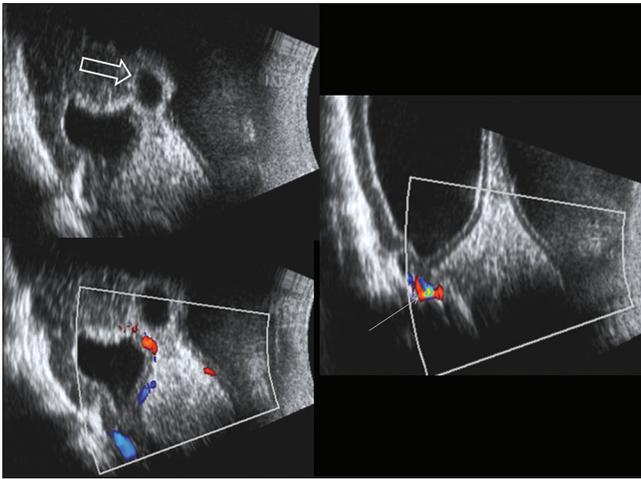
Axial examinations through the mastoid fontanelle showing a total obstruction at the level of the aqueduct. Dilated third ventricle is demonstrated by an open arrow. Incidentally Doppler flow is demonstrated in lateral sinus (long arrow)
